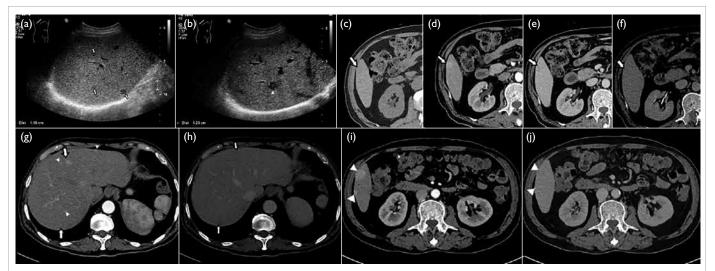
Case 1. Initial ultrasound scan revealed multiple well-circumscribed round hypoechoic hepatic lesions with central echogenic focus measuring up to 1.2 cm (white arrows and arrowhead in [a] & [b], respectively). Morphology resembles a 'bullseye' appearance and was thought to represent possible hepatic candidiasis. Subsequent multiphasic computed tomography (CT) [white arrows] revealed (c) a single hypoattenuating lesion at segment V (about 1.4 cm in diameter) demonstrating (d) arterial hyperenhancement, (e) portal venous washout and (f) delayed washout. Hepatocellular carcinoma is a possible differential for this radiological pattern. A developing left sacral lytic lesion with soft tissue component was noted on the same CT (not shown). Follow-up triphasic CT scan of the liver within 3 weeks showed multiple bi-lobar new arterial enhancing lesions (white arrows and arrowheads in [g]), (h) some with portal venous washout and delayed washout. The smaller ones (white arrowheads in [g]) were isoattenuating in portal venous and delayed phases and cannot be discretely identified. There was also rapid interval enlargement of segment V hepatic lesion, measuring up to 2.5 cm in diameter with (i) arterial enhancement, (j) portal venous washout and delayed washout (white arrowheads). Biopsy of this segment V lesion confirmed clonal plasma cells, consistent with the diagnosis of hepatic extraosseous myeloma
